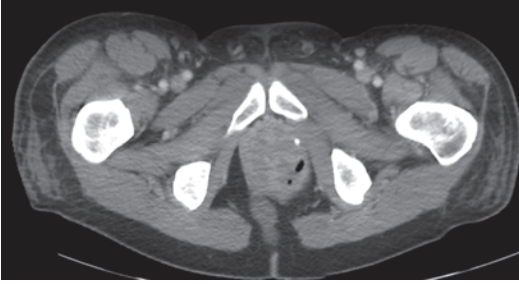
CT scan showing pelvic abscess
